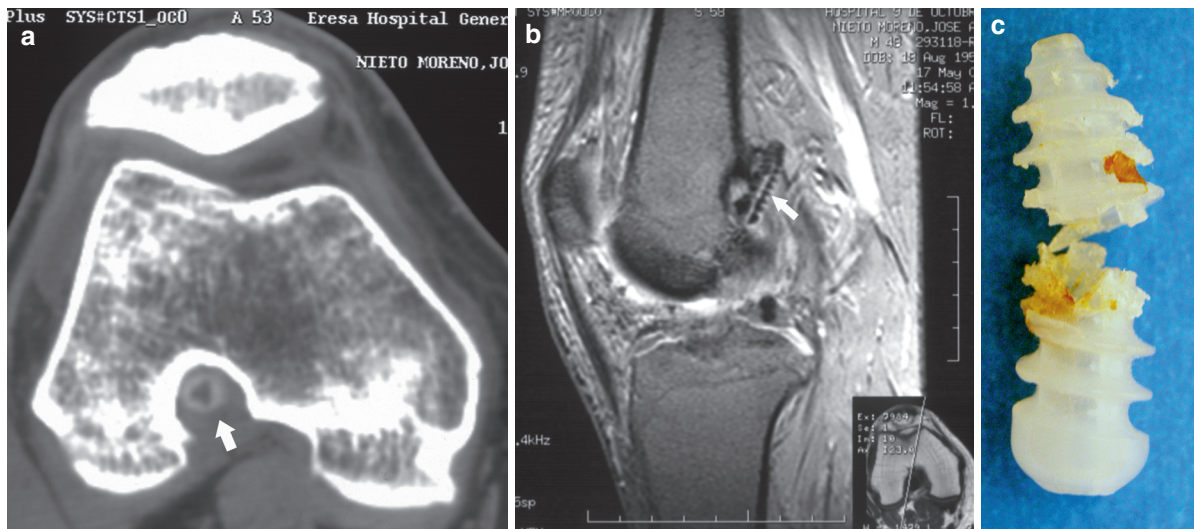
(a) Axial CT scan at 0° of knee flexion demonstrating a lateral subluxation of the patella. Femoral screw (arrow). (b) Sagittal GrE T2* MRI demonstrating a severe femoral screw/tunnel divergence. Moreover, you can note that the screw is
